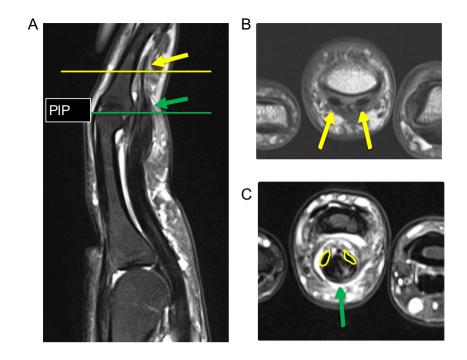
Zone 1 flexor tendon injury. A 48-year-old man with injury to right ring finger two months prior presenting with inability to flex at the distal interphalangeal joint. Radiographs showed no fracture of the distal phalanx. A Sagittal T2 fat-suppressed image demonstrates a torn flexor digitorum profundus (FDP) tendon (green arrow) at the level of the proximal interphalangeal joint (PIP) consistent with a type 2 injury. A flexor digitorum superficialis (FDS) tendon
